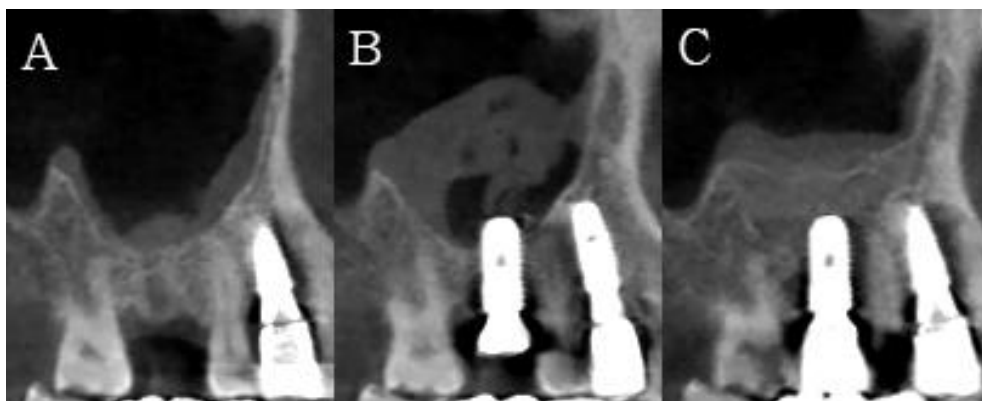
Abbreviations: CBCT, cone-beam computed tomography; E, sinus membrane elevation height; T0, residual bone height; T1, new bone height at postoperative 6 months; T2, new bone height at postoperative 12 months; G1, bone height change at postoperative 6 months; G2, bone height change at postoperative 12 months.
